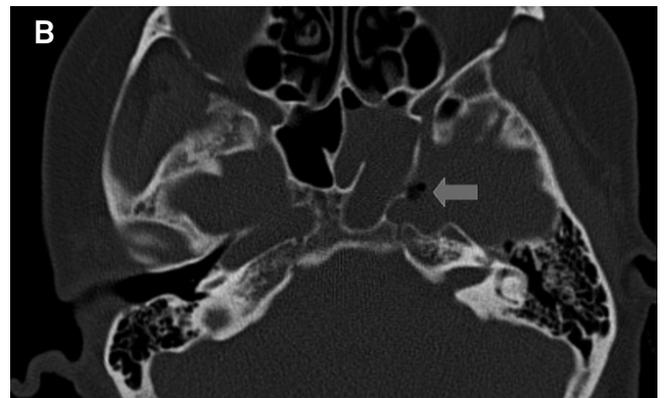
High resolution computed tomography shows opacification of the left sphenoid sinus and bone defect of the left pterygoid process (arrow) permitting the airflow through the fistula.
